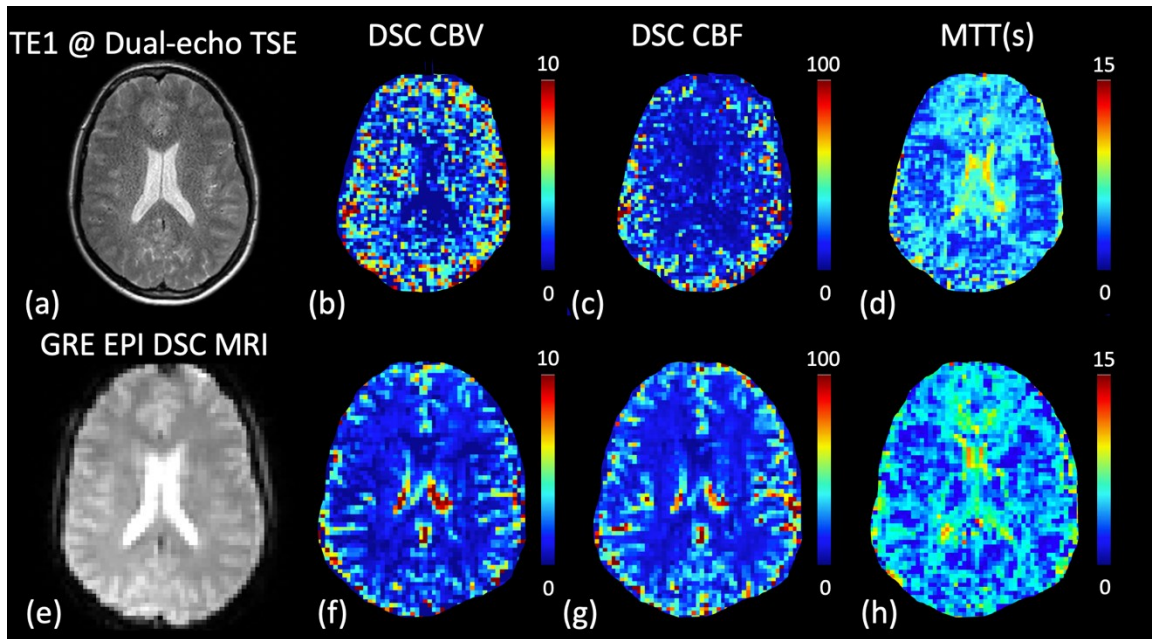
Dual-echo TSE sequence and the standard GRE EPI DSC image. Representative results for the measurement of blood perfusion from human scans using the optimized dual-echo TSE sequence (a-d) and the standard GRE EPI DSC MRI sequence (e-h) on 3T are shown. The raw MR images from the short TE ($TE1 = 80$ ms) in the proposed dual-echo TSE sequence and from the standard GRE EPI DSC sequence are displayed in (a) and (e), respectively. The derived maps of CBV, CBF, and MTT from each sequence are demonstrated subsequently. Note that the DSC CBV and CBF values are not absolute measures and thus are in arbitrary unit (a.u.). The color bars indicate the corresponding scales of each parameter. Note that the spatial resolution in the dual-echo TSE sequence ($1 \times 1 \times 2$ mm³) was higher than the standard GRE EPI DSC sequence ($2.8 \times 2.8 \times 5$ mm³). The approximately same slice location is shown in the figure.
